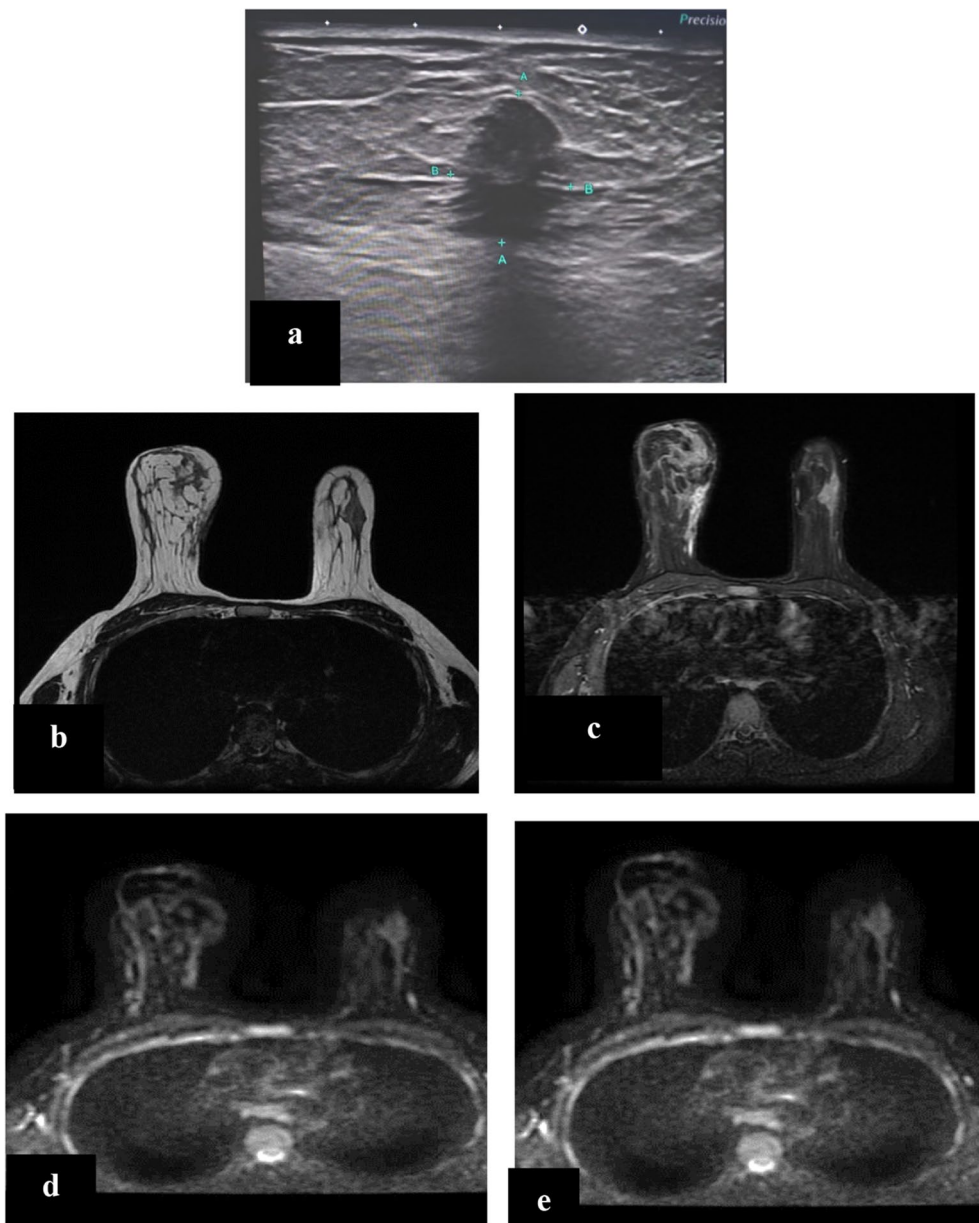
37-year-old female patient with negative family history, history of right conservative breast surgery (pathology: ILC and LCIS). a Sonographic image, showing rather defined hypo echoic soft tissue lesion with irregular outlines seen involving UIQ of right breast and not respecting surrounding tissue planes BIRADS IV. No abnormality detected at left breast BIRADS I. b, c MR T2WI and STIR show an abnormal signal intensity soft tissue lesions seen at UIQ of right breast as well as at the UOQ of left breast, they attain hypo intense signal at T2WI (b) and hyper intense signal at STIR (c). d, e, f DWI on b value 500, 1000 and 1500, respectively, ADC map g the lesion on the right breast shows T2 black out effect, while the suspicious area at the left side shows no diffusion restriction with high ADC values. So the DWI was equivocal in the right breast lesion and denied any suspicious lesion in the left breast. h, i Post contrast study, with the subtraction image, the lesion on right breast attains non-mass heterogeneous enhancement at early phases with wash out at delayed phases with kinetic curve III. Regarding the suspicious area on left breast, it attains focal area of non-mass faint heterogeneous enhancement with kinetic curve type I (RT MR BIRADS IV Lt MR BIRADS II). Pathology: Right breast: ILC. Left breast: Adenosis
